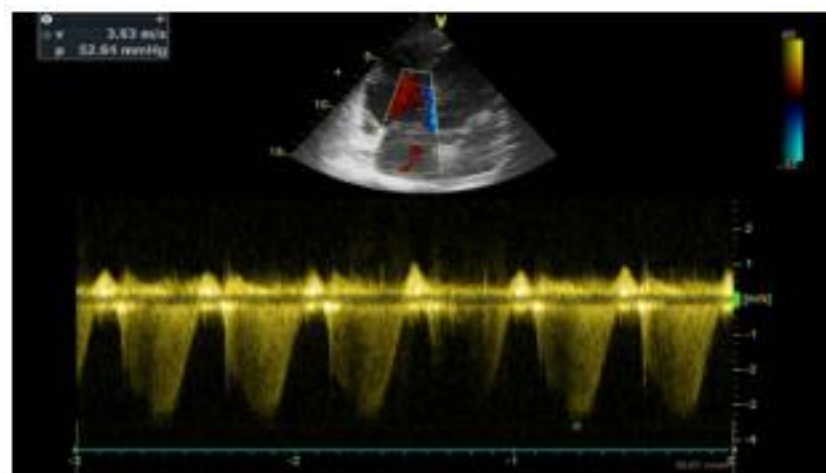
Transthoracic cardiac ultrasound - systolic pressure in pulmonary artery 52 mmHg → pulmonary Hypertension
